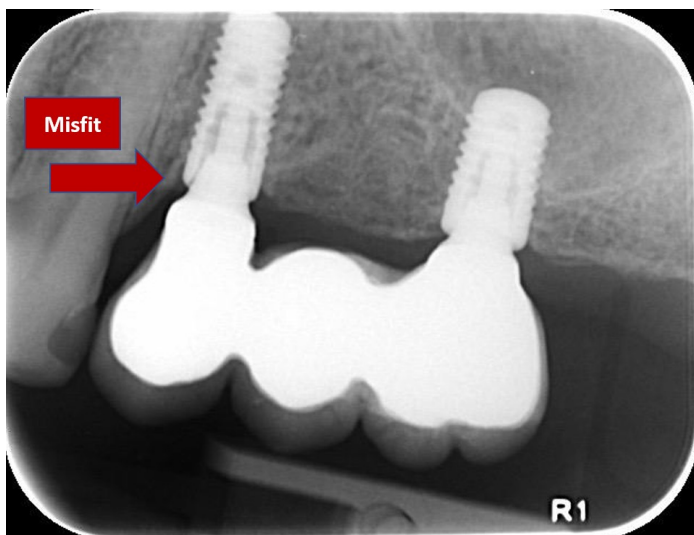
Red arrow indicates implant-abutment misfit on this periapical x-ray image of an implant retained bridge. Image from internet.
